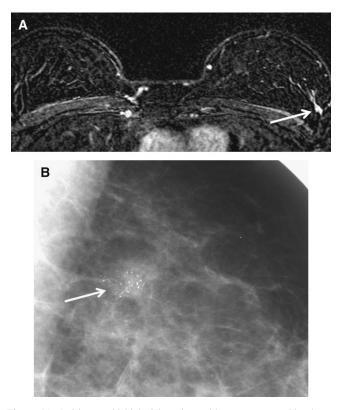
A 34-year-old high-risk patient with a mammographic abnormality that corresponded to the magnetic resonance imaging lesion. (A) Axial contrast enhanced subtracted T1 WI at 2 minutes, showing a linear, irregular area of nonmass enhancement at 2 o'clock in the left breast (arrow). (B) Magnified mediolateral oblique view of the left breast, demonstrating suspicious microcalcifications at the same site (arrow), which permitted a diagnosis of ductal carcinoma in situ with stereotactic biopsy. A mammogram 8 months earlier had been normal at that site.
